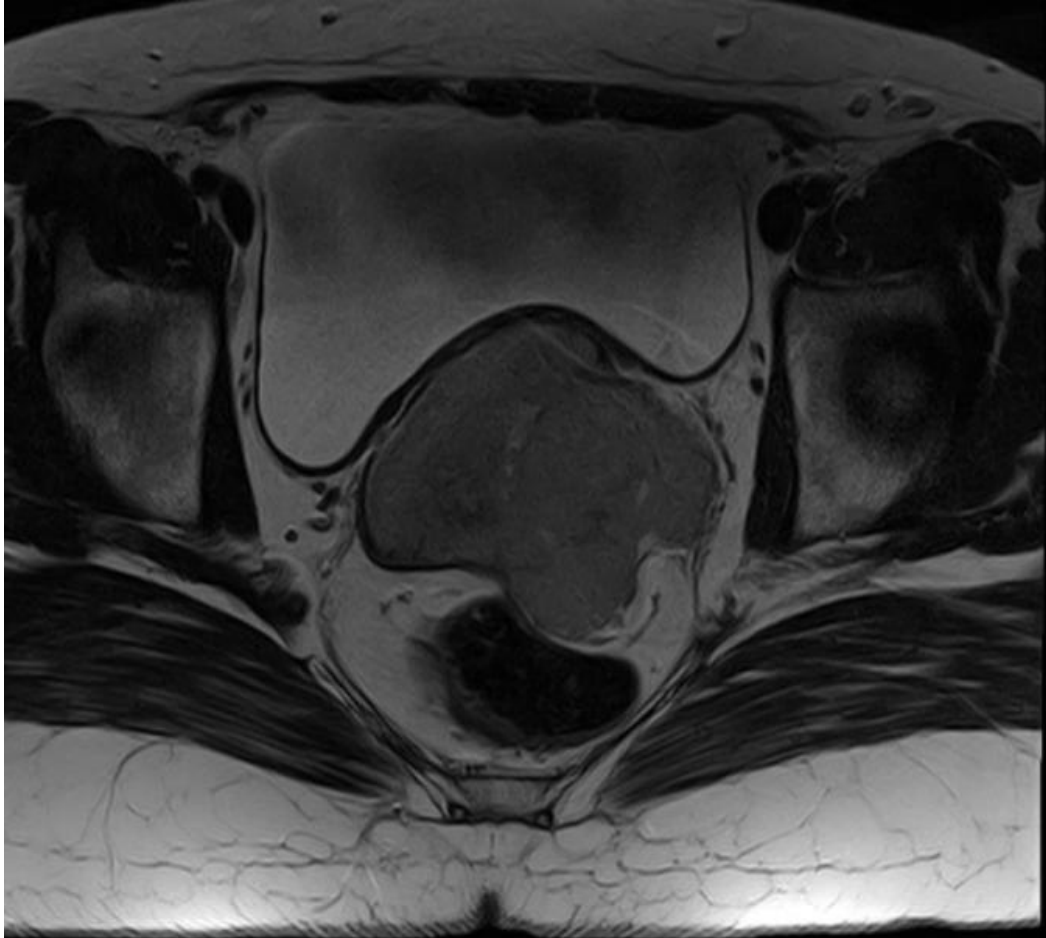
An axial section MRI of the pelvis showing a large encapsulated heterogenous mass
